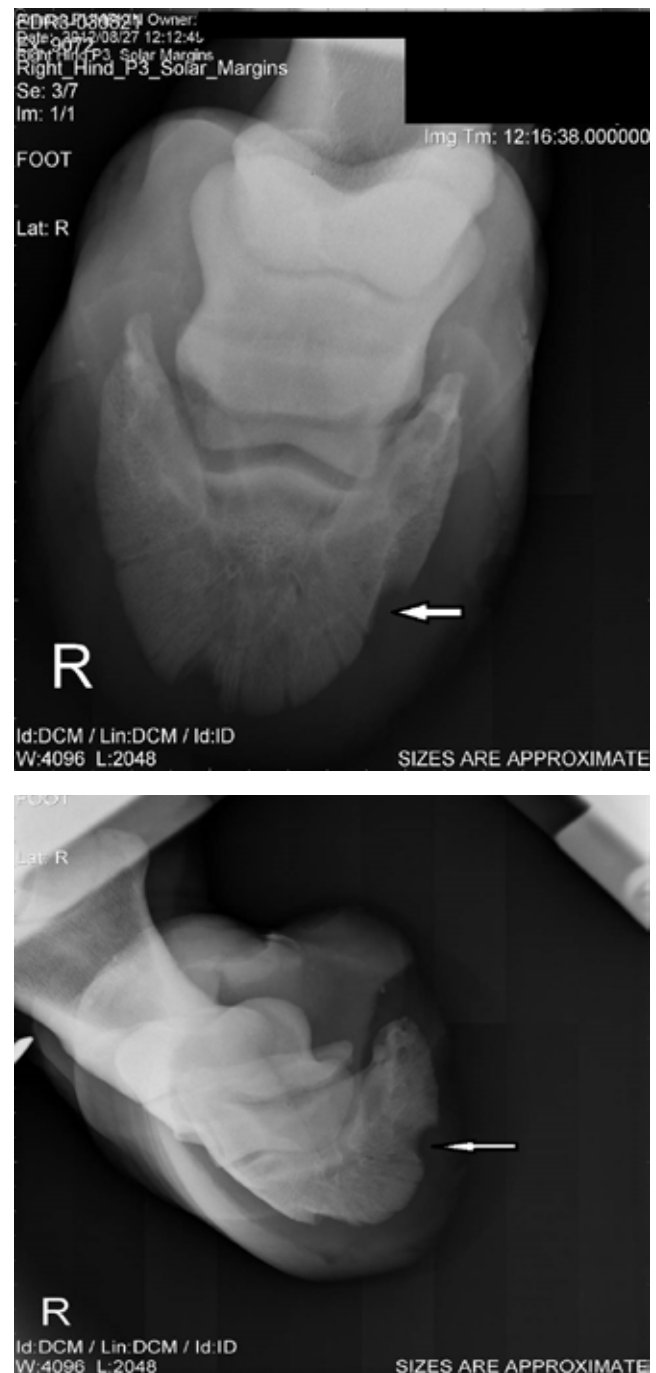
Radiographs of the right hind P3 solar margin. Arrows show radiolucent defects within the distal phalanx.
